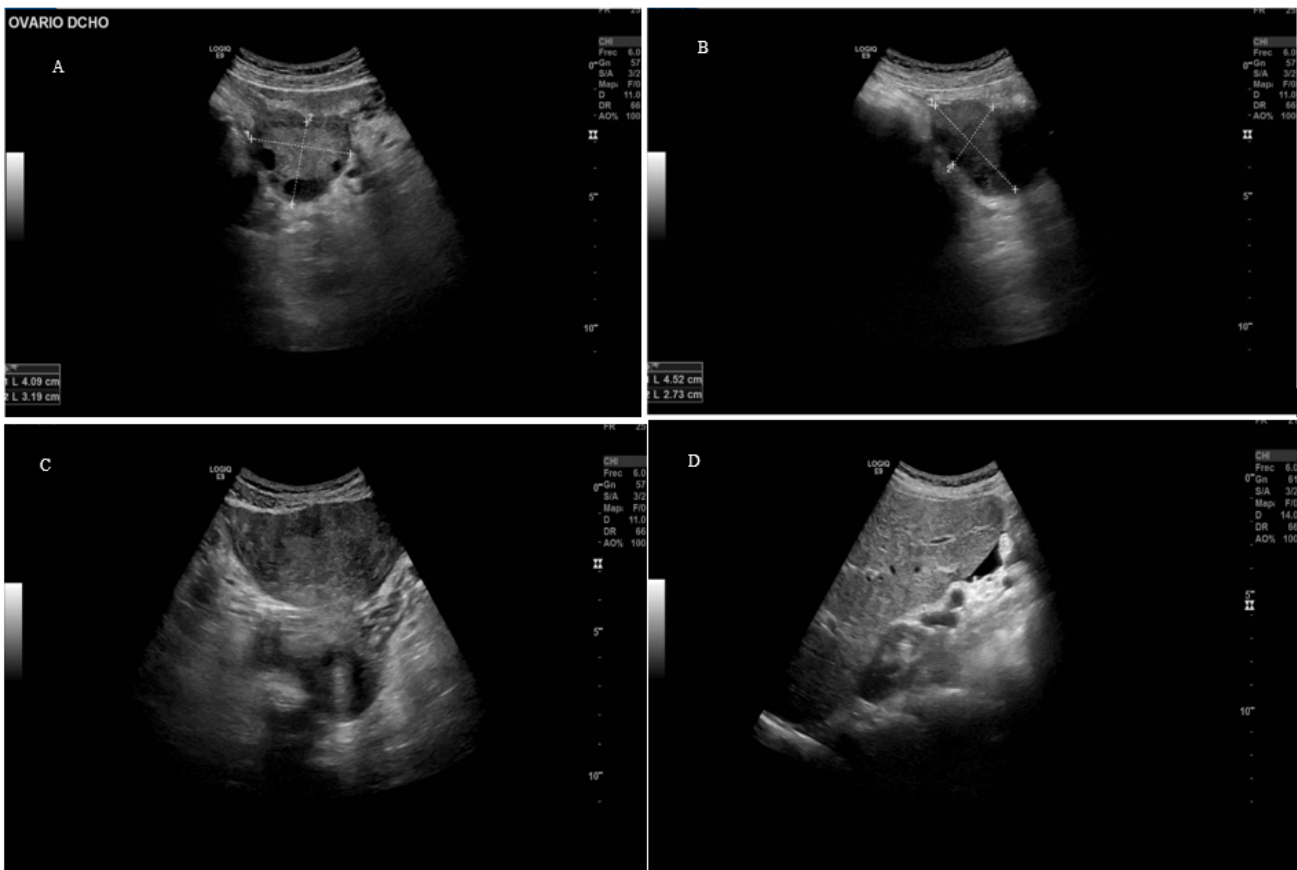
Abdominal ultrasound. (A,B) Both ovaries with normal eco-structure. (C) Cross-section on the uterine background, where you can see the absence of peritoneal liquid at the pelvic level. (D) Absence of peritoneal liquid at level peri-hepatic.
